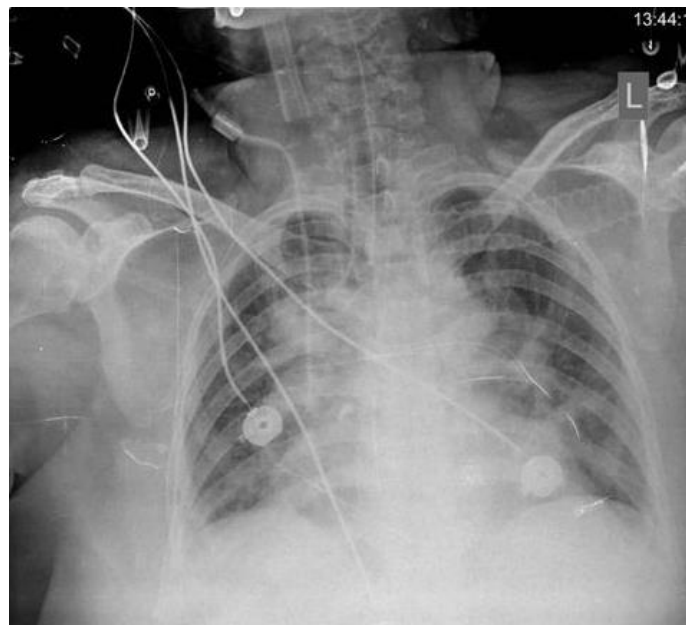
Initial chest CT scan showing bilateral pulmonary infiltrates consistent with viral interstitial pneumonia.
